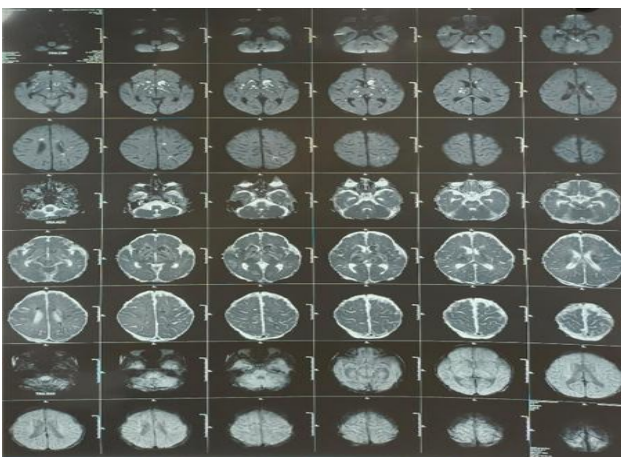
(DWI/ADC) bilateral basal ganglia infarcts.
